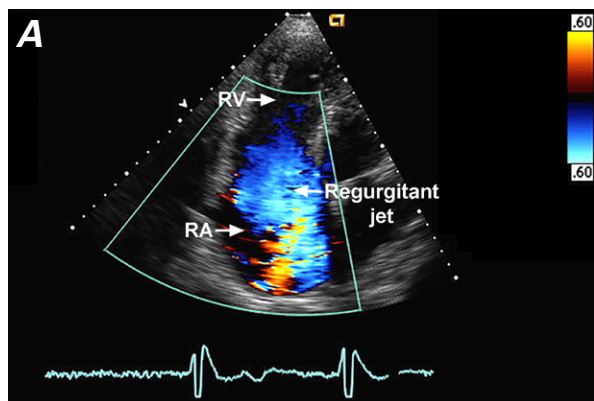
Preoperative transthoracic echocardiograms. A) Four-chamber view (color-flow Doppler mode) shows severe tricuspid regurgitation. B) Four-chamber view shows tricuspid valve (TV) remnants and marked right ventricular and right atrial dilation.
